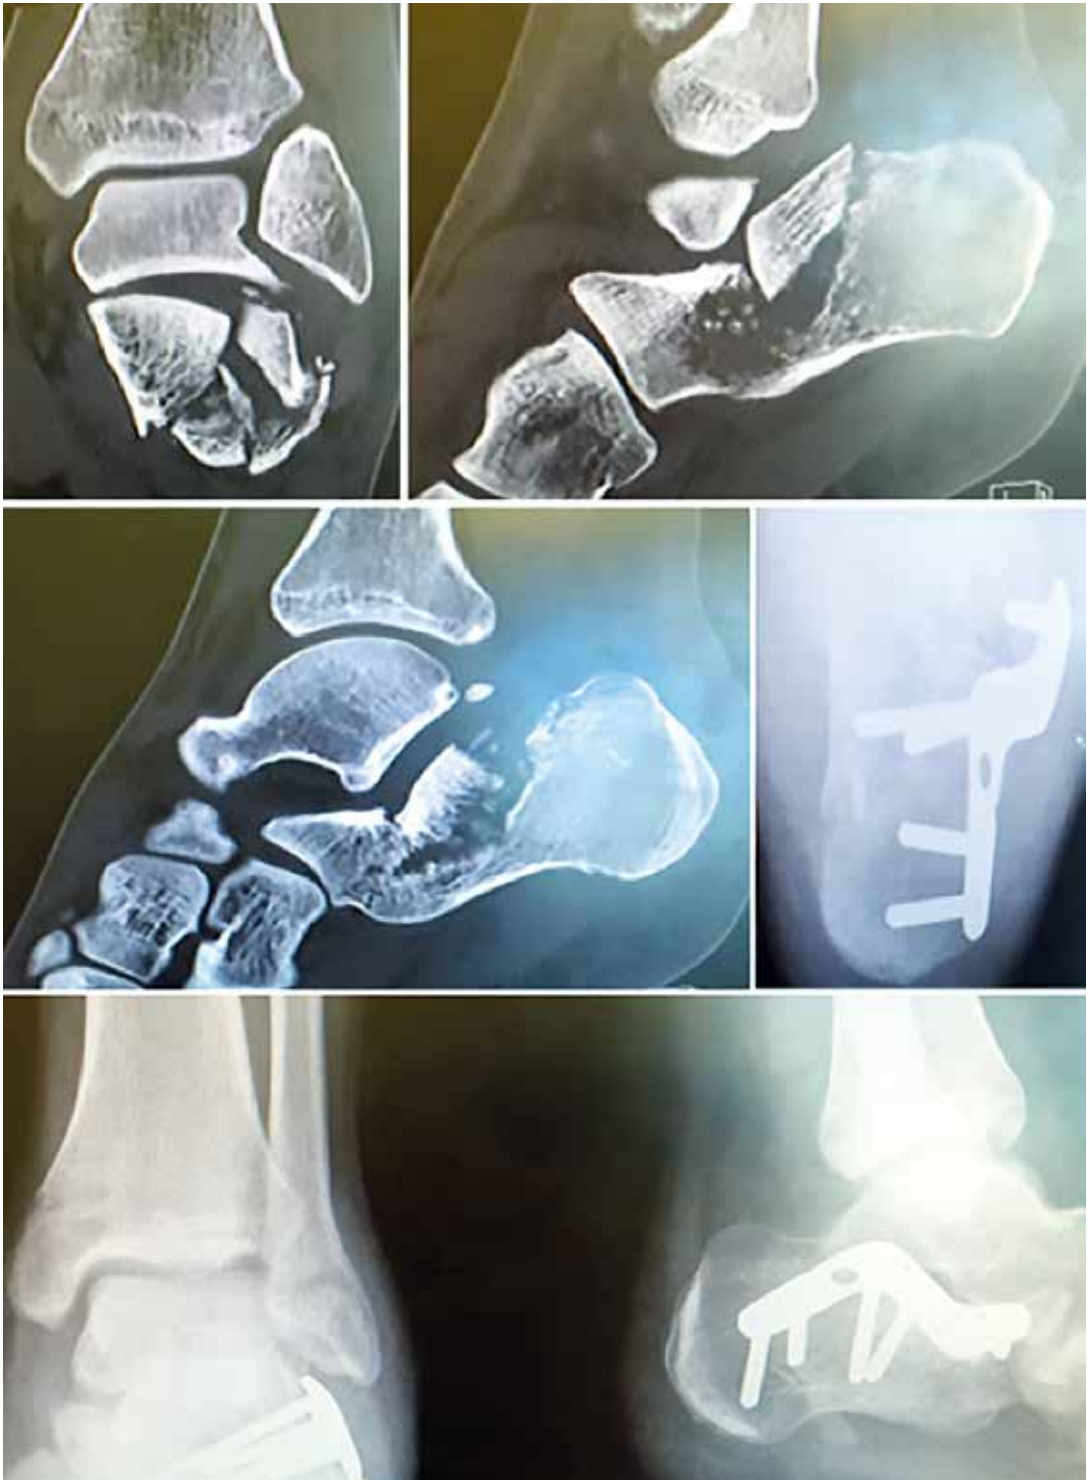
Pre-operative CT scan of a 28-year-old patient with a displaced intra-articular fracture and post-operative radiographs following operative fixation using the Wave plate.
